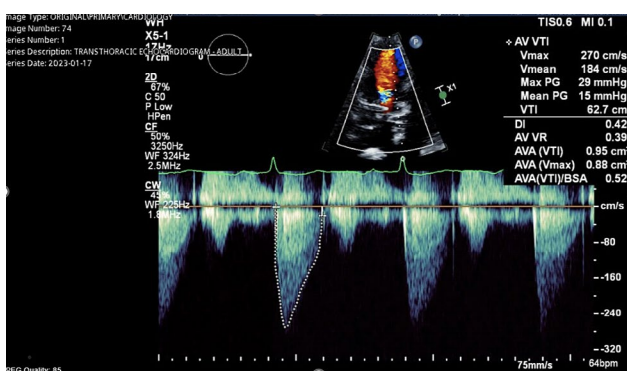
Transthoracic Echocardiogram Demonstrating Mild Aortic Stenosis
